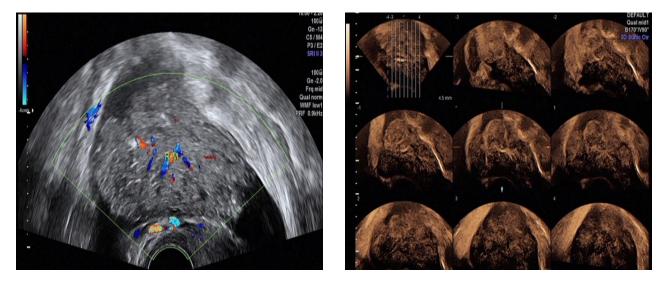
A serious adenocarcinoma (stage Ia). A) Transvaginal sonogram showing a solid area with irregular contours and blood flow within it and ascites (thick arrow). B) 3D-CEUS shows a significant, inhomogeneous enhanced region in the parenchyma. Stereoscopic vascularity and clear courses of blood vessels (thin arrow) can be seen in every layer of the 3D TUI-CEUS. The GI-RADS combination with 3D-CEUS system score was 6.
